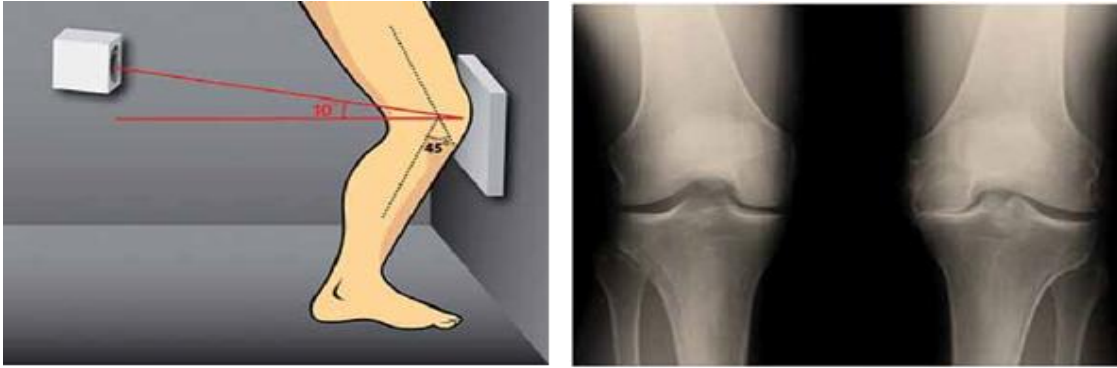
The Rosenberg view of the knee. The patient stands with knees flexed approximately 45° against the image receptor while bearing weight. A posteroanterior X-ray beam angled about 10° caudally opens the posterior tibiofemoral joint spaces, allowing sensitive assessment of joint space narrowing and early degenerative changes.
